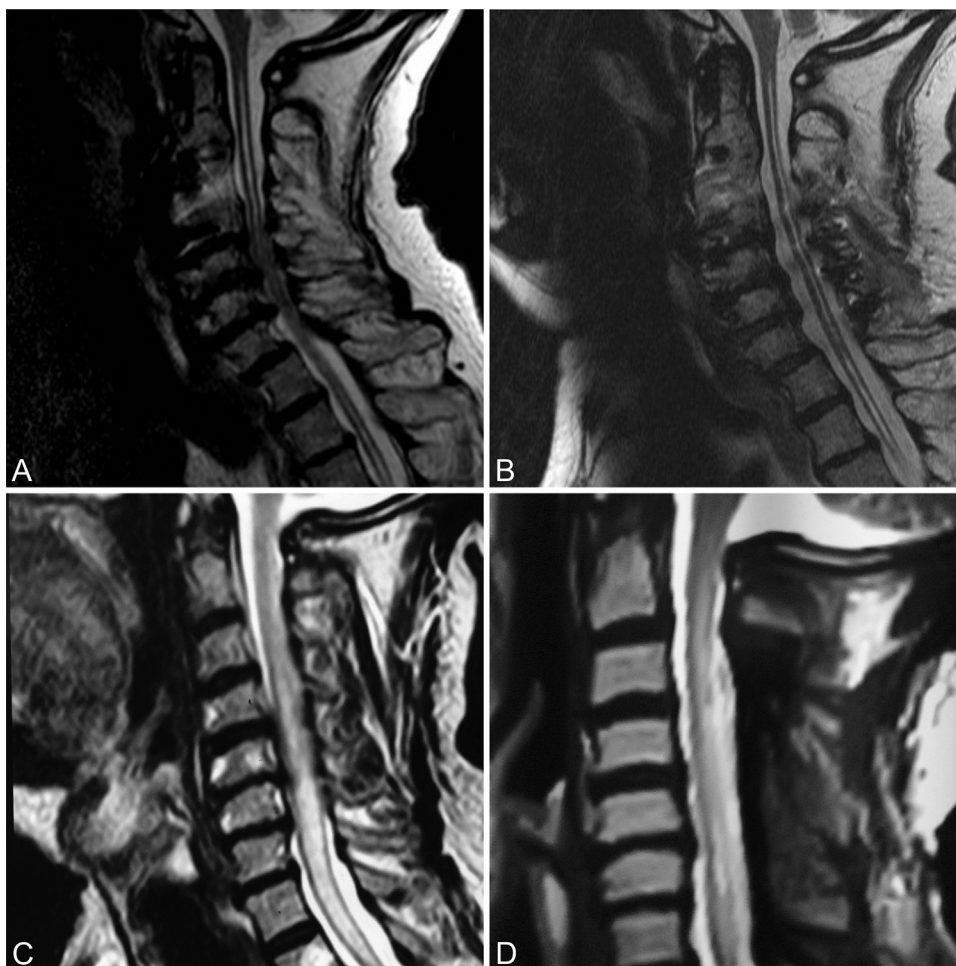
Sagittal T2 cervical MRI of two patients showing preoperative cervical canal stenosis and syringomyelia (A, C) and postoperative decompression with laminoplasty (B) and laminectomy (D) with marked reduction in the size of the syrinx.
